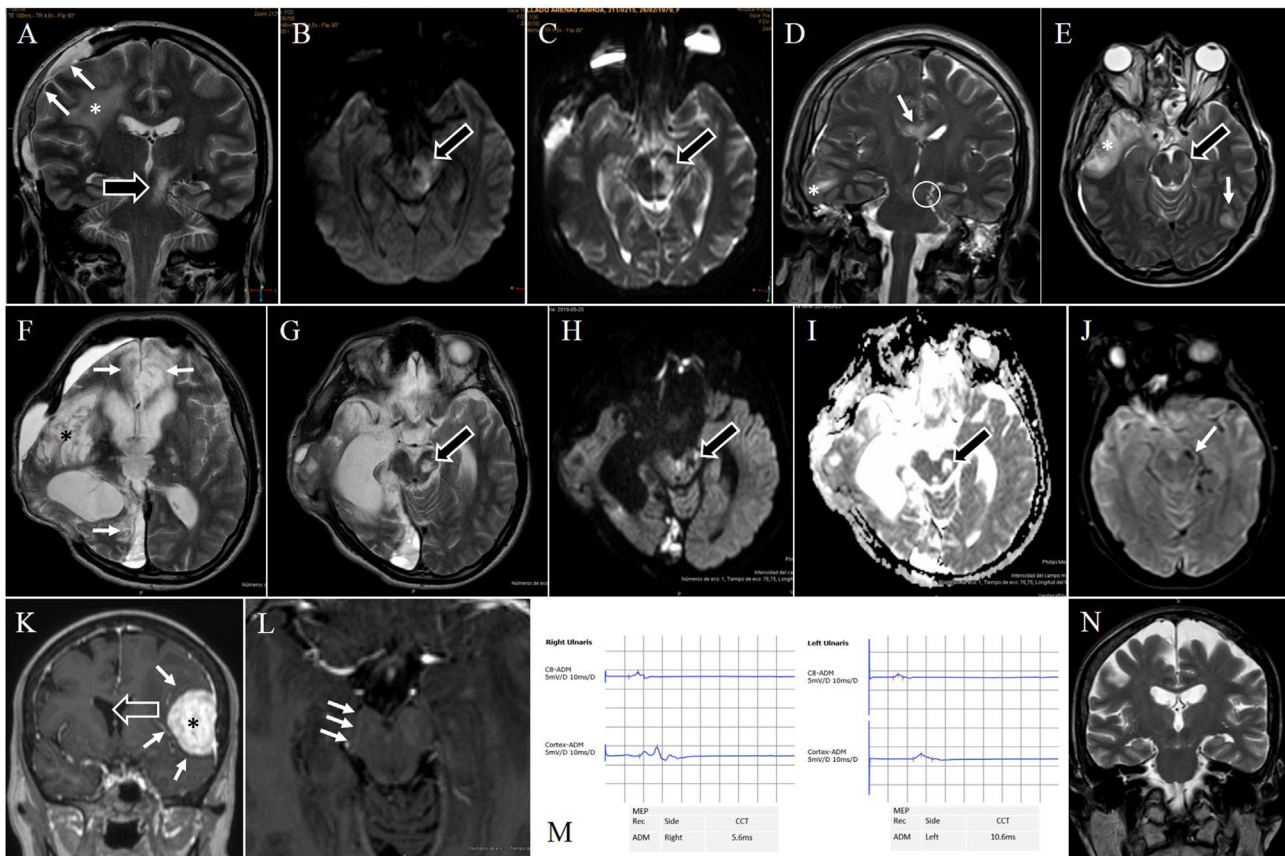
Selection of the most relevant findings from diagnostic studies in our series. (A-C) Patient 1. Brain MRI scan performed after right frontotemporoparietal craniectomy and drainage of an abscess in the right frontal lobe. A) T2-weighted sequence (coronal view) revealing residual oedema in the right frontal brain parenchyma (asterisk), with mild brain herniation through the craniectomy defect (white arrows), as well as a hyperintense lesion in the left cerebral peduncle (black arrow), located at the level of the tentorial notch and extending along the longitudinal axis. B) Diffusion-weighted sequence revealing signal hyperintensity involving the left midbrain nearly completely (arrow), with no evidence of diffusion restriction on the ADC map (C; arrow). (D-E) Patient 2. Postsurgical MRI scan, T2-weighted sequences (D: coronal view; E: axial view). Signal hyperintensity in the right temporal lobe, associated with contusion (asterisks in D and E). Residual tentorial notch in the left cerebral peduncle (white circle in D) associated with a hyperintense lesion at the ventrolateral edge of the peduncle (arrow in E). The MRI scan also revealed other hyperintense lesions involving the axons of the left posterior temporal corticosubcortical region and the corpus callosum (white arrows in D and E). (F-I) Patient 3. Postsurgical MRI scan. F) T2-weighted sequence (axial view) at the level of the interventricular foramina, showing morphological alterations following decompressive craniectomy, with brain herniation through the bone defect and ventricular dilation associated with communicating hydrocephalus. The image also reveals signs of chronic ischaemia in the territories of both anterior cerebral arteries and the right posterior cerebral artery (white arrows in F), as well as malacia following the resolution of contusion foci in the right temporal lobe and insula (asterisk in F). G) T2-weighted sequence (axial view) at the level of the midbrain revealing a lesion in the central region of the left cerebral peduncle, with identical signal to that of cerebrospinal fluid on T2- and diffusion-weighted sequences and on ADC maps (black arrows in G, H, and I, respectively). (J) Patient 8. Magnetic susceptibility sequence showing haemosiderin deposition at the level of the lesion in the left cerebral peduncle (white arrow). (K-N) Patient 11. Preoperative MRI. A T1-weighted sequence following paramagnetic contrast administration (K: coronal view; L: axial view) showed an extra-axial expansive process in the greater wing of the left sphenoid bone (asterisk in K) associated with peripheral vasogenic oedema (white arrows in K), resulting in a mass effect with midline shift to the right (transparent arrow in K), causing deformation with flattening of the right cerebral peduncle secondary to compression against the tentorial notch (white arrows in L). A motor evoked potential study (M) revealed slower central conduction time and decreased amplitude in the right corticospinal tract (transcranial magnetic stimulation of the right motor cortex; recording in the left abductor minimi digiti). N) Follow-up MRI scan (coronal T2-weighted sequence) performed after surgical resection of meningioma, showing disappearance of the mass effect, with brain structures returning to the normal anatomical position, and no signs of structural lesions at the level of the right peduncle.
